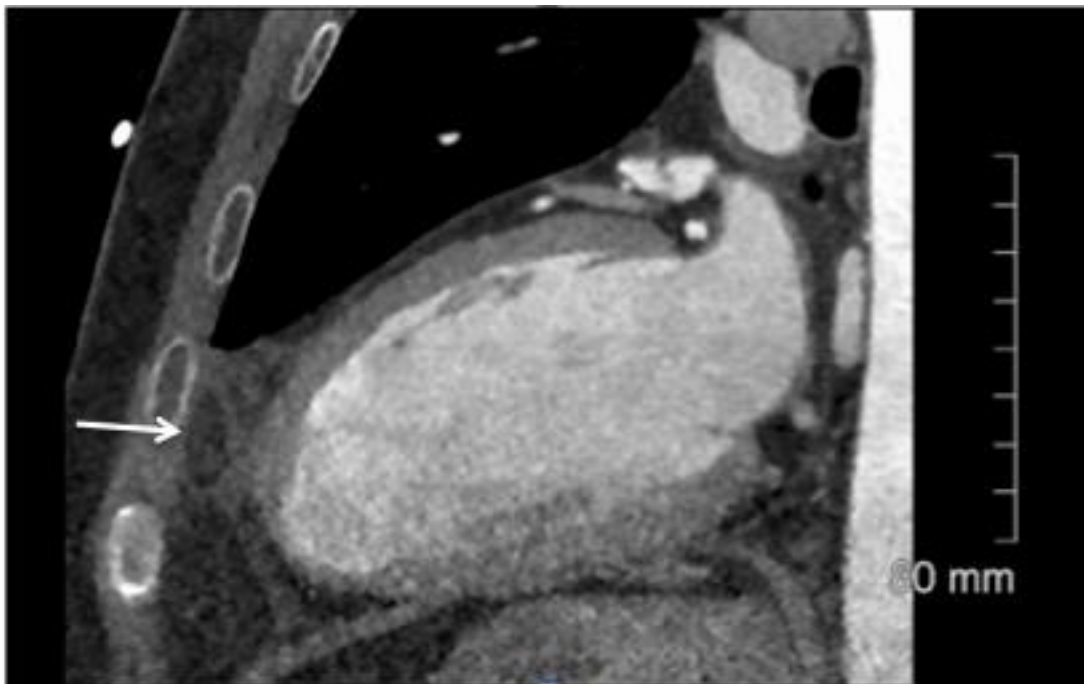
Vertical long axis CT scan shows a well-defined fatty lesion (arrow) with marked surrounding fat stranding.
